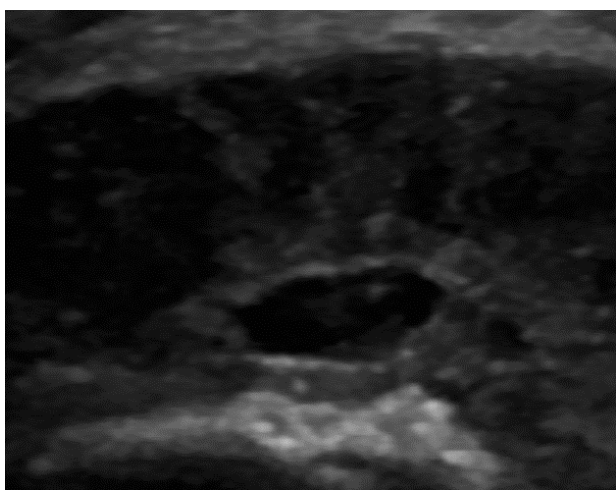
Transverse ultrasound of patellar tendinopathy with area of fibrillar rupture (hypoechoic foci surrounded by connective reinforcement). Tendon degeneration in its most proximal and deep portion (critical area to receive higher tensile strength during tissue stress).
